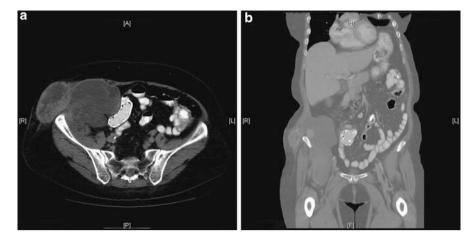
CT of dedifferentiated liposarcoma with retroperitoneal trans pelvic extension into thigh (a, b)
